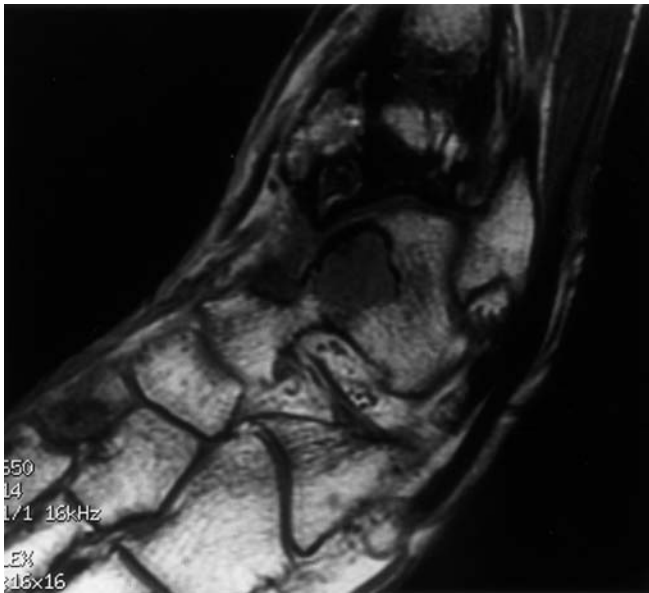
Oblique coronal T1-weighted MR image showing new lesions in the cuneiform and the talus
